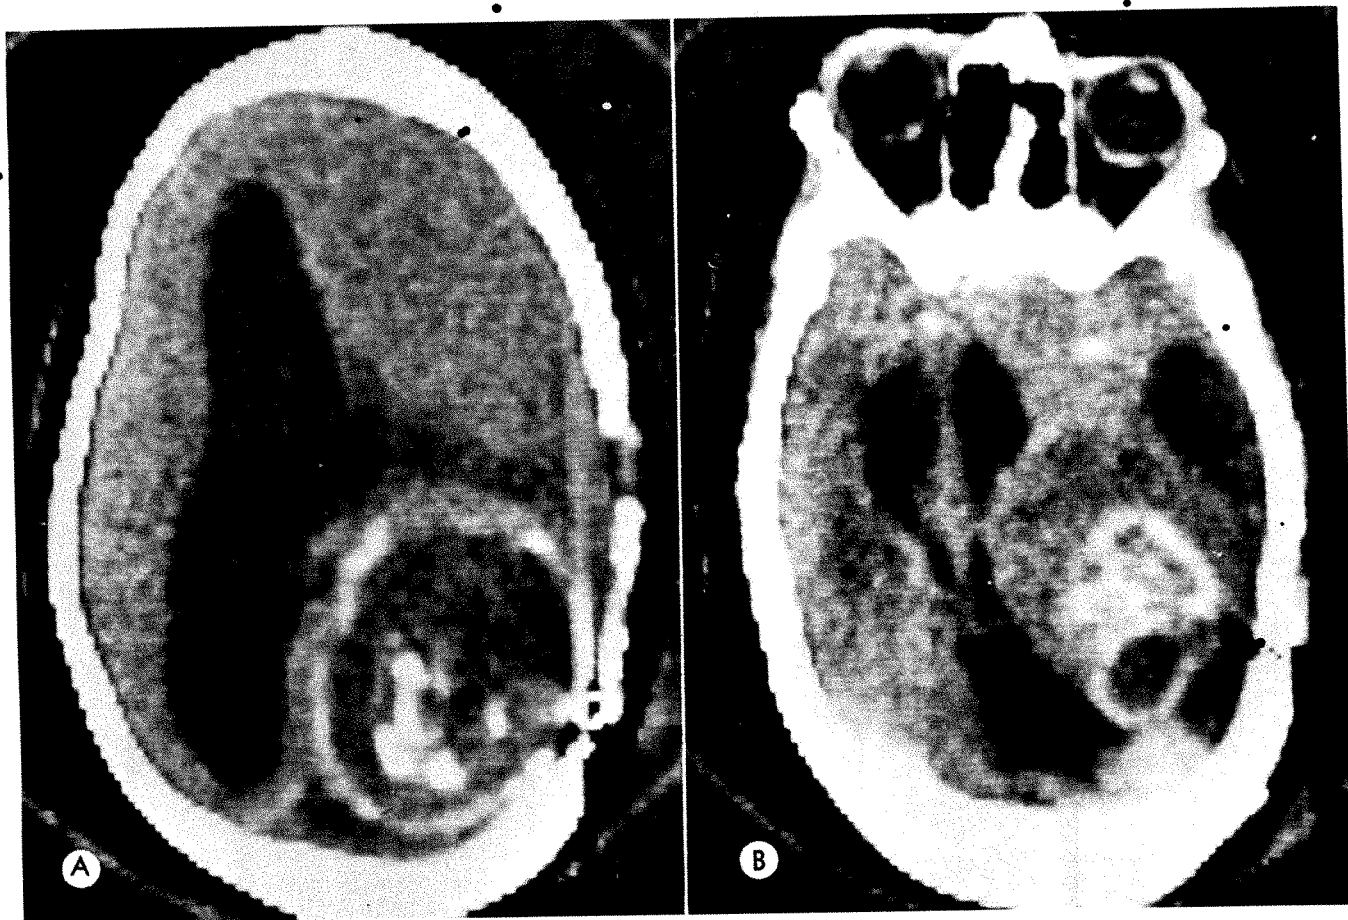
Chronic abscess with daughter abscesses. 7-year-old male with repeated infection of shunts for hydrocephalus post meningitis. Right parieto-occipital abscess operated on 1 year ago. Presents now with clinical deterioration. A, CT scan at level of occipital horns showing calcified chronic abscess capsule with calcified debris within it, effaced right lateral ventricle, and markedly dilated left lateral ventricle. Craniotomy site and shunt hardware over abscess capsule. B, Scan after contrast showing multiple enhanced daughter abscesses extending inferiorly and forward into basal ganglionic region.
